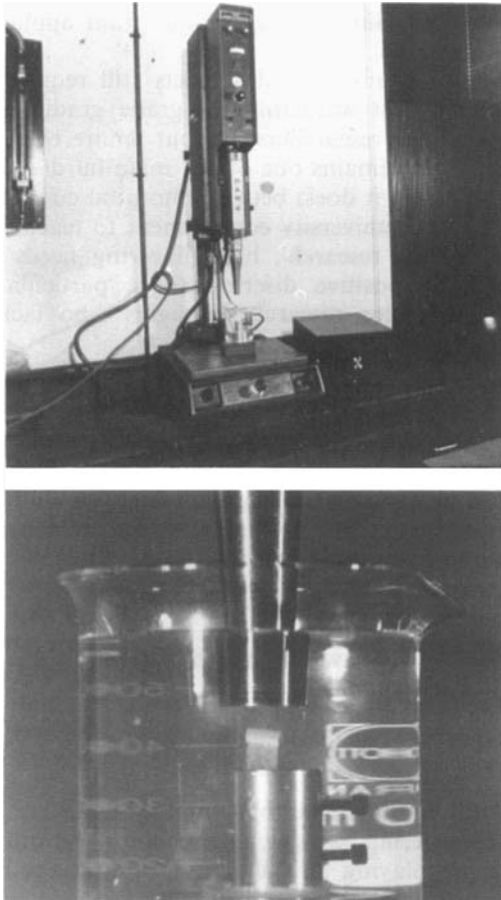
To investigate the effect of cavitation on human cartilage tiny samples were subjected to cavitation produced, in saline, by high-intensity ultrasound
